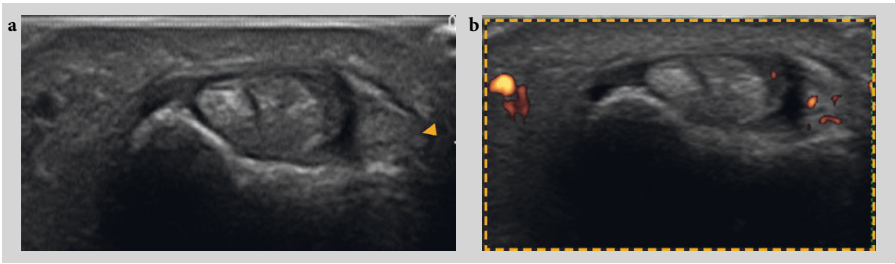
An ultrasound normal aspect of extensor ulnaris carpi in a transverse scan. (a) Grayscale alone. (b) Normal power Doppler signal due to normal feeding vessels within tendon sheet.
